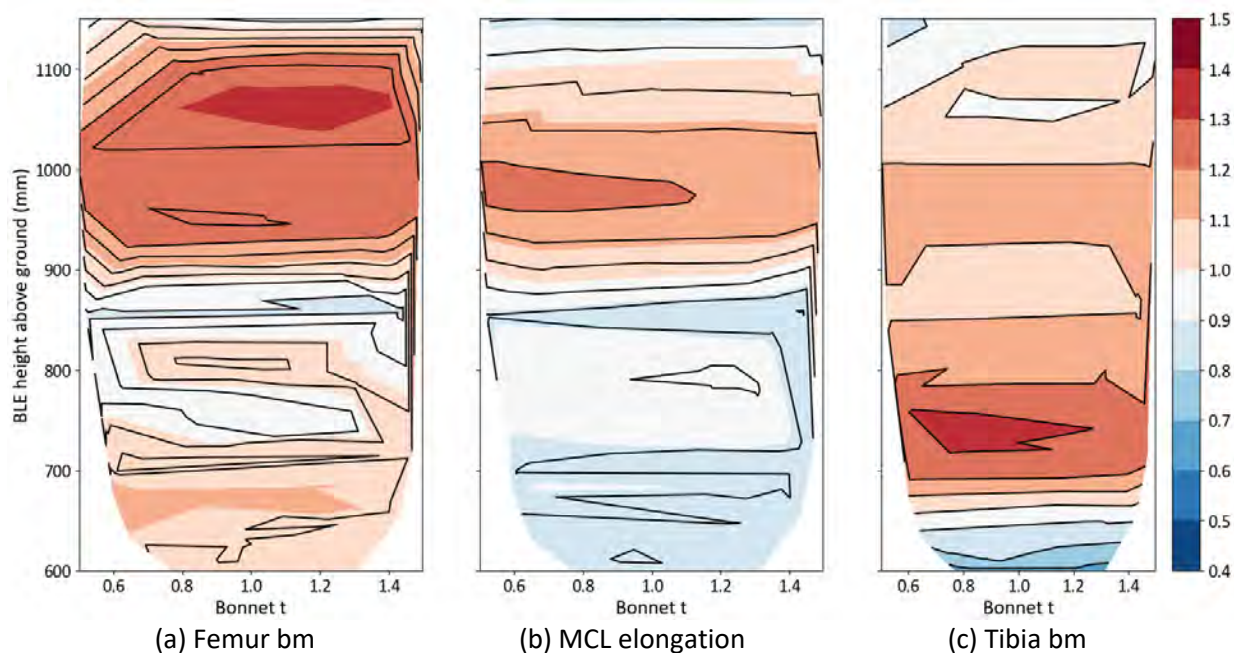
Normalised maximum aPLI injury values at test position Y+600 for the SUV by varying the exterior sheet thickness of the bonnet and the shooting height of the impactor (converted to BLE height above ground).
